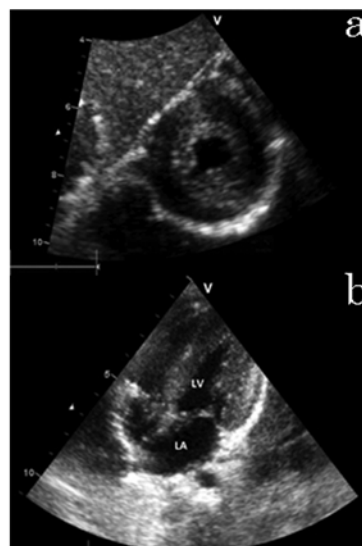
a. Short axis transthoracic echocardiographic image showing grossly thickened myocardium in the same child 6 months later. b. Apical four chamber echocardiographic image at the age of 11 months.
